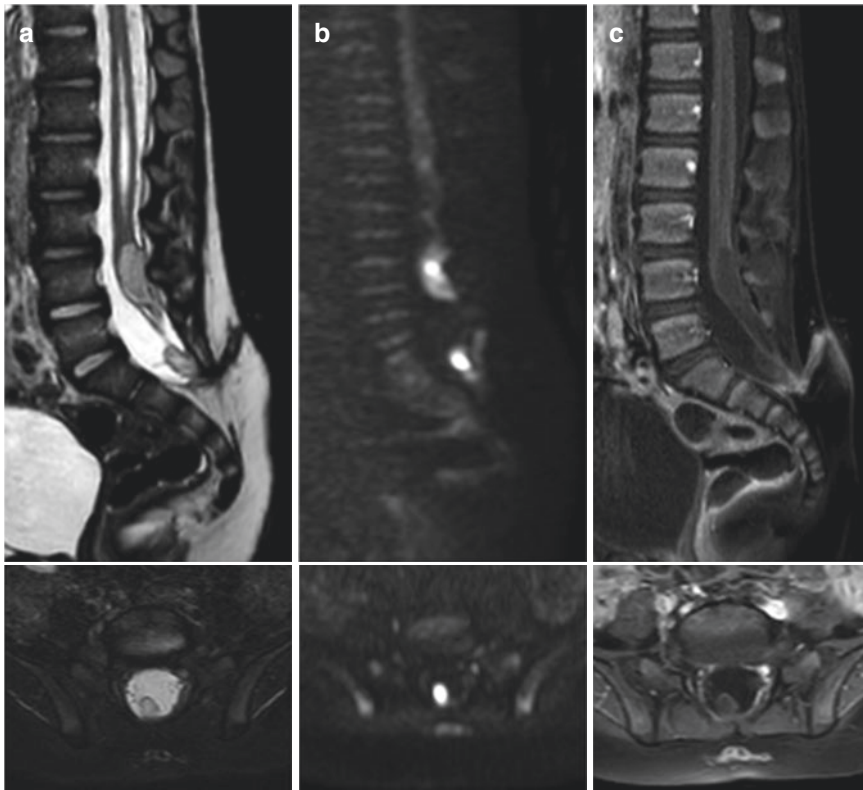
MR appearance of spinal dorsal dermal sinus tract with intradural infection. T2-weighted (a), DWI (b) and GD-enhanced fat suppressed T1-weighted (c) images on the sagittal and axial planes. MRI shows expansion of the medullary conus by hyperintense epidermoid lesion in patient affected by tethered cord. A dermal sinus tract with marginal contrast enhancement, suggestive of inflammatory process, extending from the subcutaneous plane to subdural collection is evident. Note the restricted diffusion and thin hypointense rim with contrast enhancement, suggestive of a capsule. Note the distal central canal dilatation with slight enhancement of the ependyma
